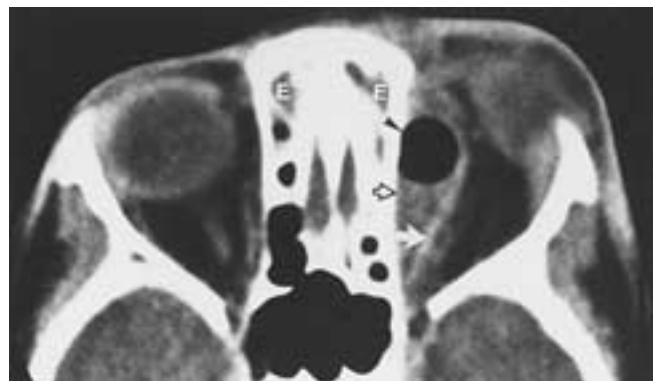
Orbital subperiosteal abscess. CT scan shows proptosis of the left eye with mucosal thickening of the ethmoid air cells (*E*), with subperiosteal abscess (*hollow arrow*). Note the air bubble (*arrowhead*) within the abscess and the swollen left medial rectus muscle (*arrow*).
